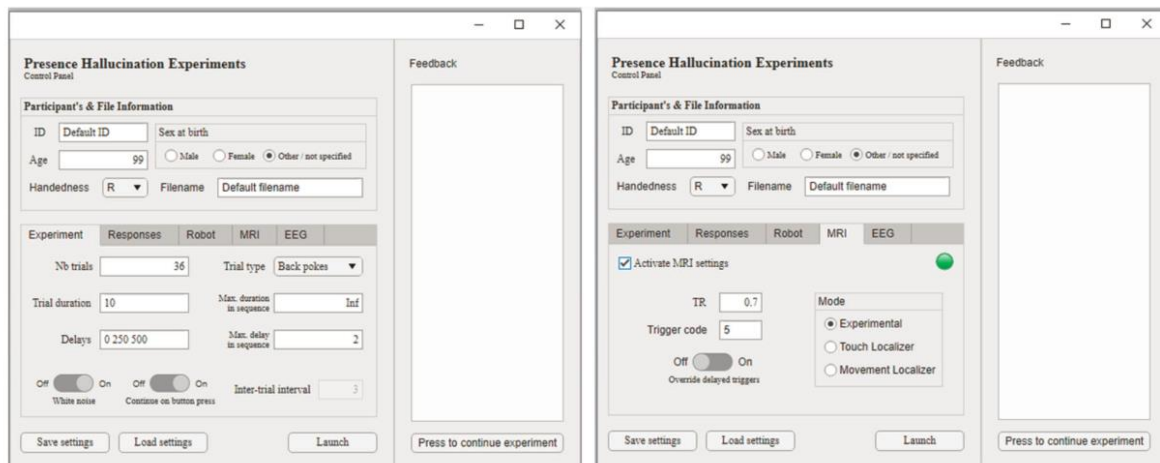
GUI for behavioral experiments. Left: view of the GUI with default values to conduct behavioral experiments. Each parameter can be adapted depending on the experimental needs. Positioning the cursor on the parameter icon will provide additional information on the role of the selected parameter. Right: GUI displaying the MRI settings. View of the GUI with default values to conduct behavioral experiments. Each parameter can be adapted depending on the experimental needs. Positioning the cursor on the parameter icon will provide additional information on the role of the selected parameter. By selecting 'Activate MRI settings' it will be possible to conduct MRI experiments.
